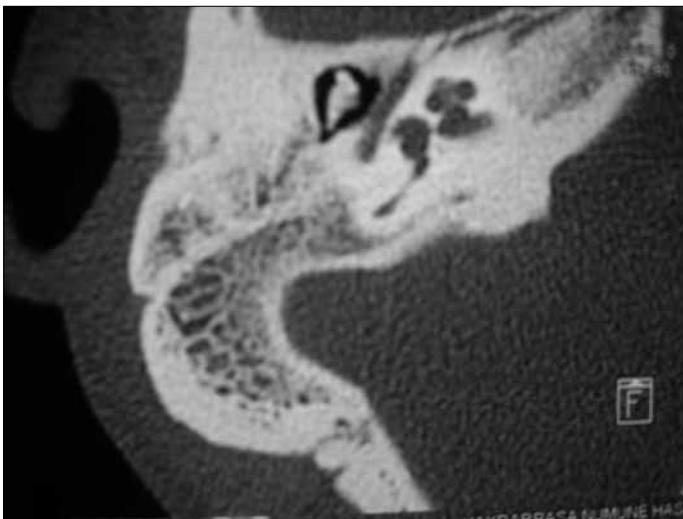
Axial CT scan of left temporal bone
